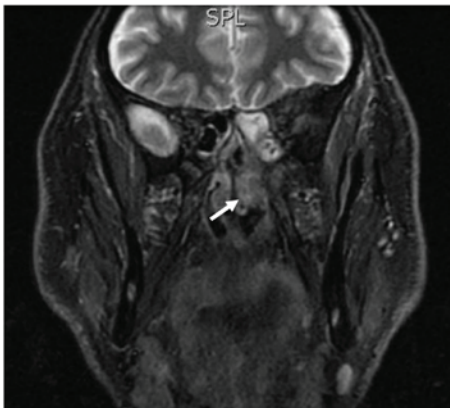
MRI scan of the mass in the left middle nasal cavity with extension to the homolateral ethmoid and no bony erosion as indicated by the white arrow. MRI, magnetic resonance imaging.
